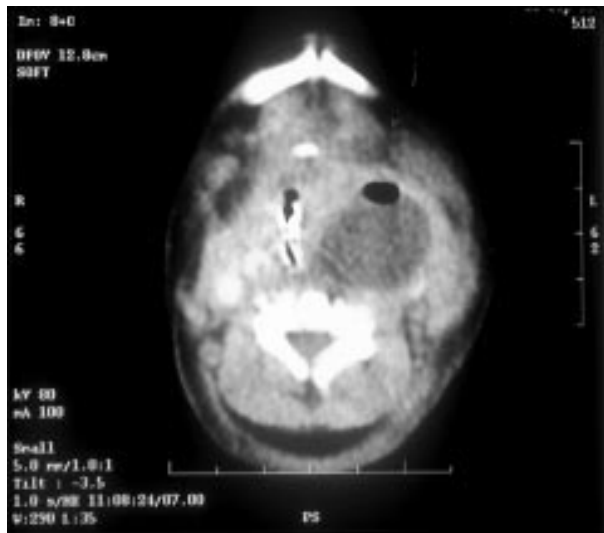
Computed tomographic scan of the neck showing a left sided retropharyngeal abscess with a typical air bubble anteriorly with the baby supine.
